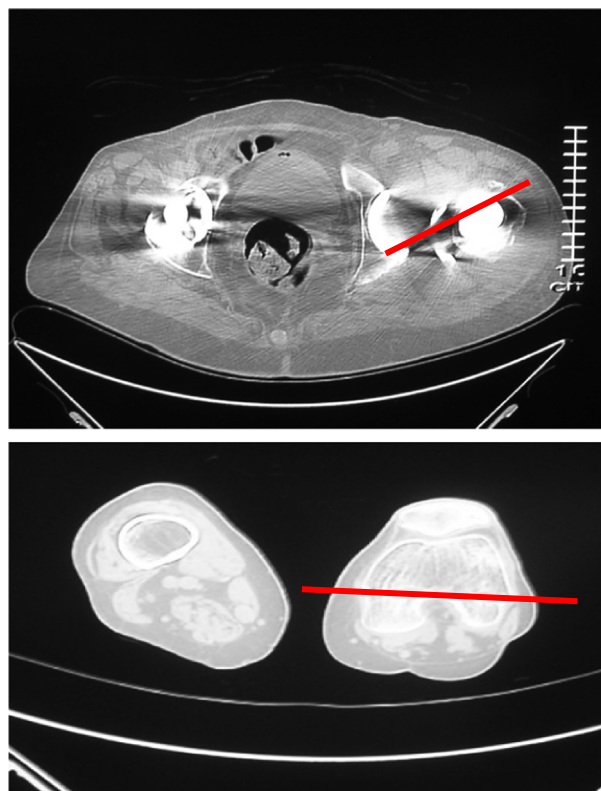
Figure – Type II Instability: this combined CT scan of the femoral neck and trans-epicondylar axis demonstrates retroversion of the femoral prosthesis. Courtesy of Craig J Della Valle, MD.
